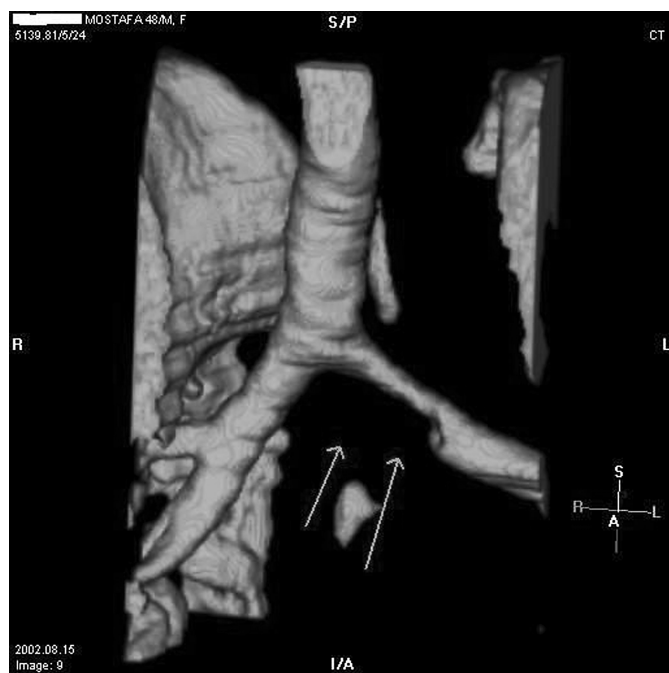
Three-dimensional reconstruction of thoracic CT scan showing severe left main stem bronchial stenosis.
